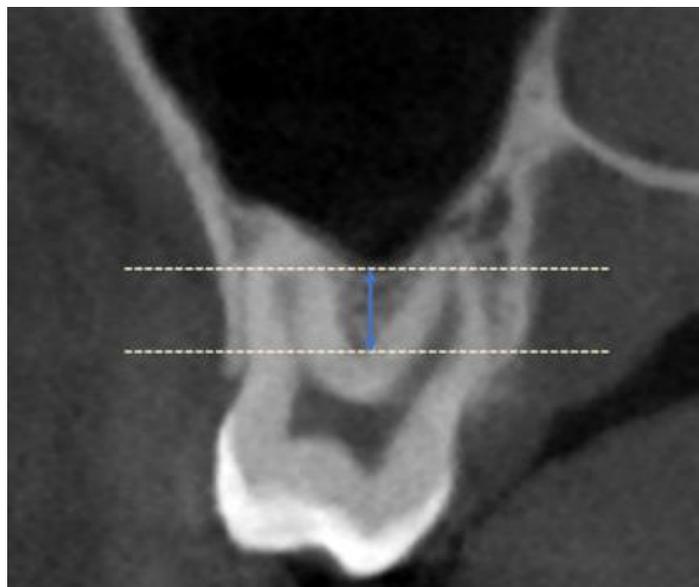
Measurement of the shortest vertical distance from the furcation midpoint to the sinus floor on CBCT images
